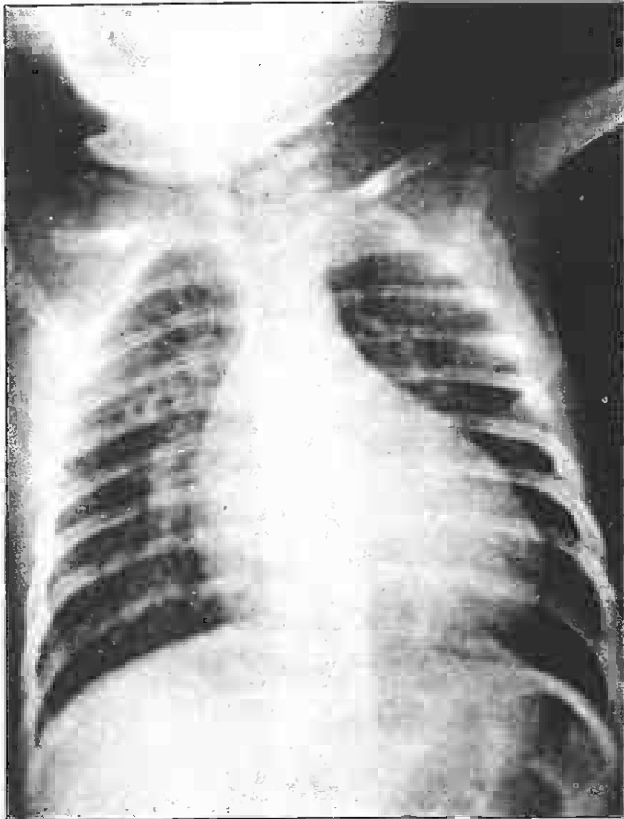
Chest roentgenogram showing egg-shaped heart of transposition of great arteries with narrow pedicle and gross pulmonary plethora.
